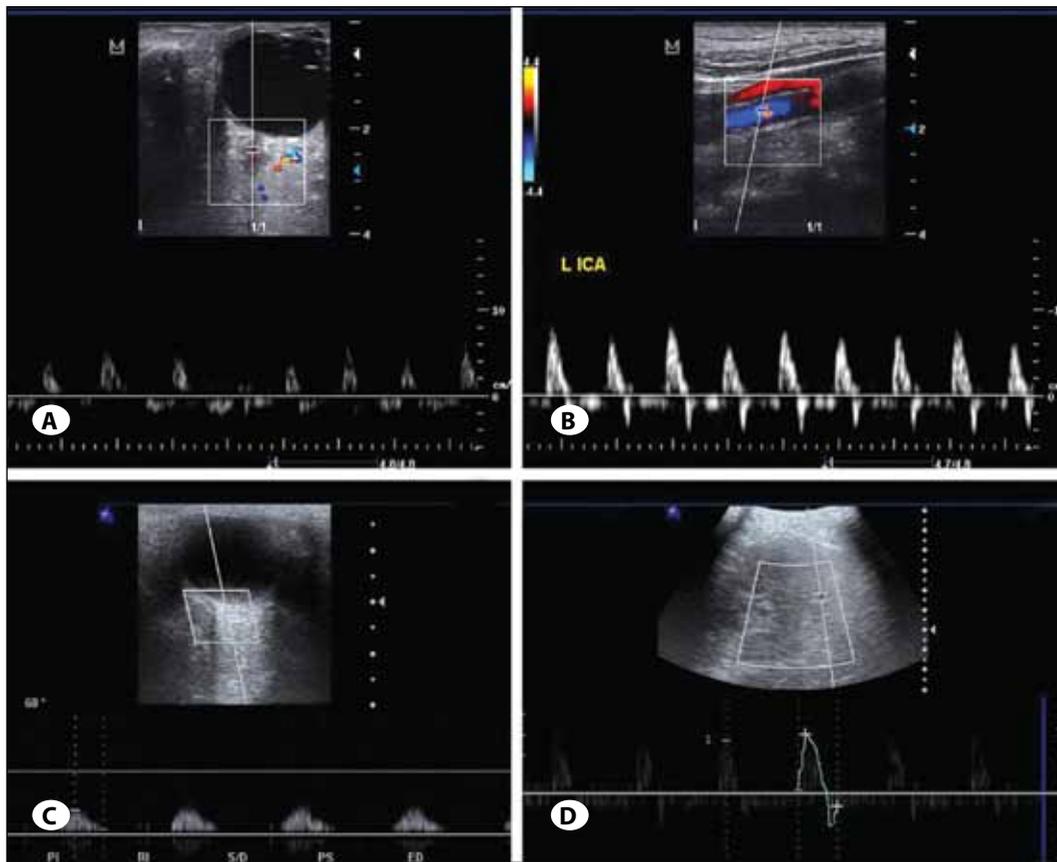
Doppler ultrasound (DUS) images of a 68-year old female patient with right ICA occlusion (patient no: 15). A) DUS examinations performed from the central retinal, B) left internal carotid, C) ophthalmic, and D) middle cerebral arteries revealed high RI values ($RI \geq 1$) which were compatible with brain death. Cessation of the flow ($RI = 1$) during systole in the ophthalmic artery and presence of reverse flow ($RI > 1$) in other arteries are observed.
